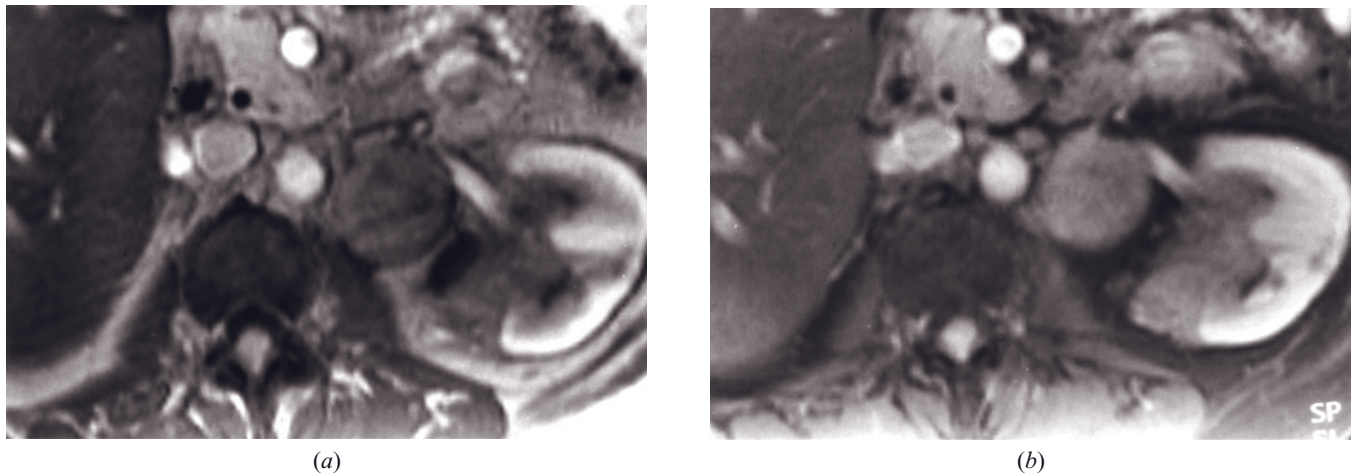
Extramedullary hematopoiesis. T1-weighted immediate (a) and 90-s fat-suppressed (b) postgadolinium SGE images in a patient with myelofibrosis. The left kidney demonstrates an infiltrating soft tissue mass involving the hilum and extending into the renal parenchyma. A large rounded focus of this process is also observed in the left para-aortic region.
